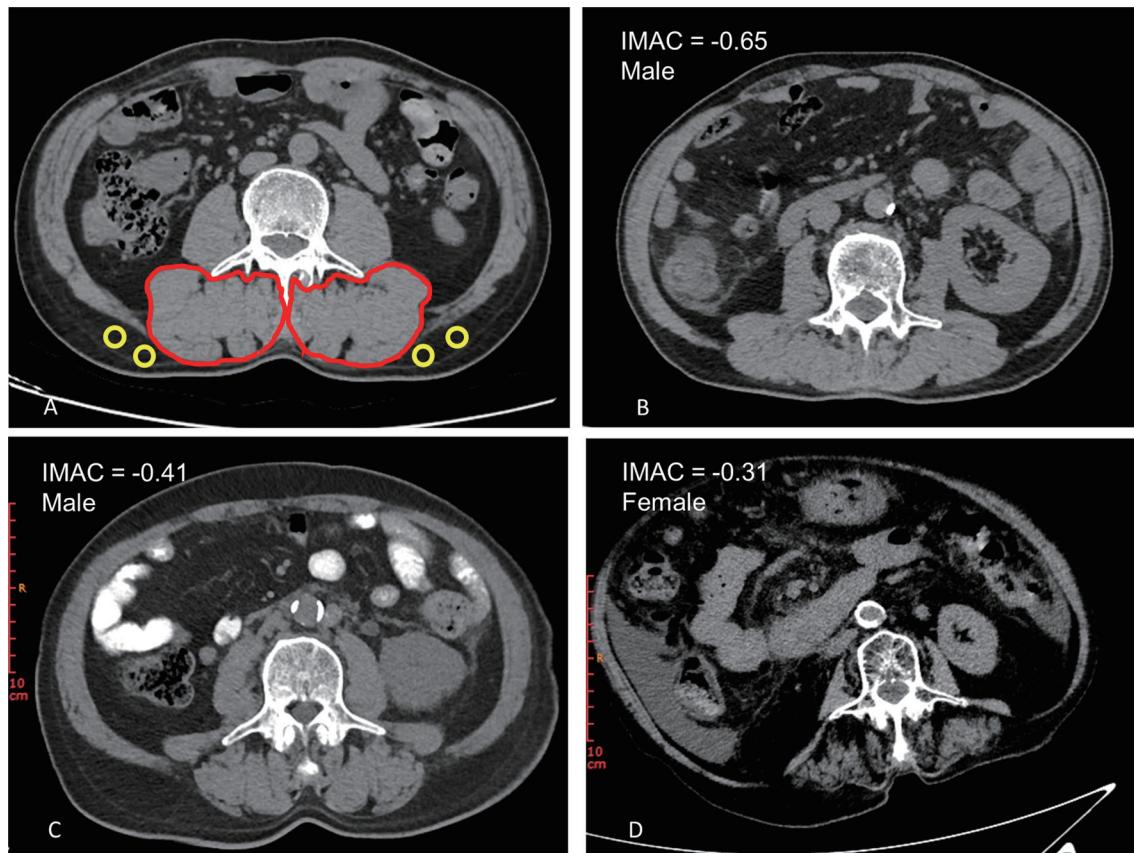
Abdominal computed tomography images taken at the third lumbar vertebra to quantify intramuscular adipose tissue and muscle radiodensity in patients with cirrhosis. (A) Cross-sectional computed tomography image of subfascial muscular tissue in the multifidus muscle (two red circles) and subcutaneous fat (four yellow circles). (B) Cross-sectional computed tomography image for a male patient with IMAC of -0.65 . (C) Cross-sectional computed tomography image for a male patient experiencing myosteatosis with IMAC of -0.41 . (D) Cross-sectional computed tomography image for a female patient experiencing myosteatosis with IMAC of -0.31 . IMAC, intramuscular adipose tissue content.
